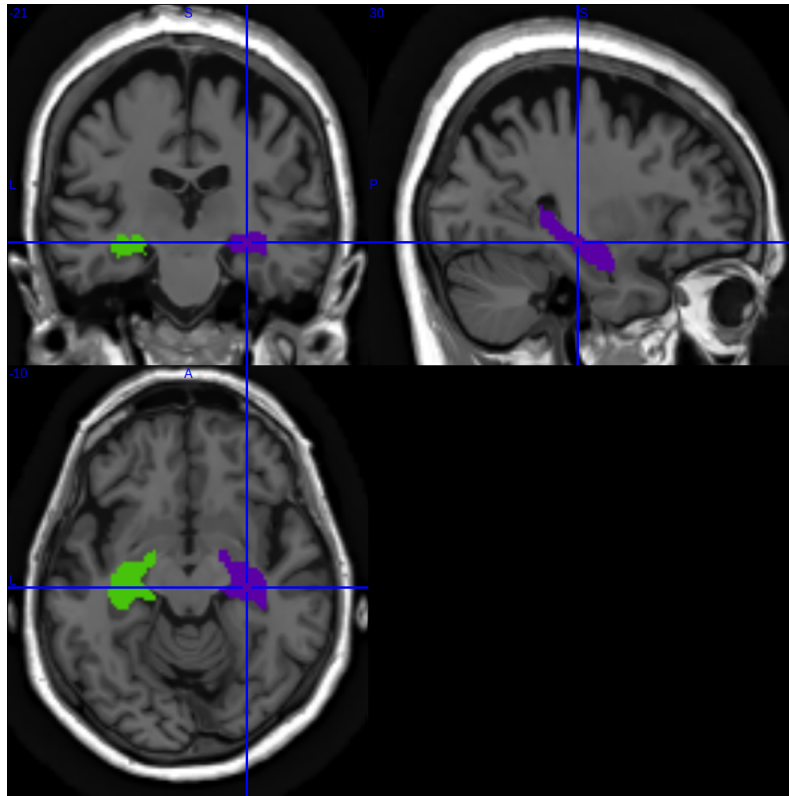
Hippocampus ROI selection in three planes of an MRI slice
